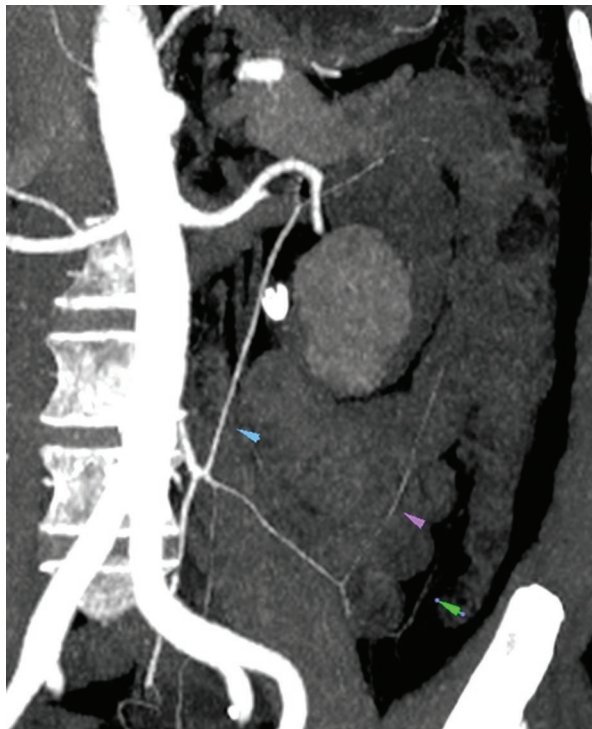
Two dimensional-computed tomography angiography: left to right vascular arcades of Moshkovich, Riolan and Drummond.
